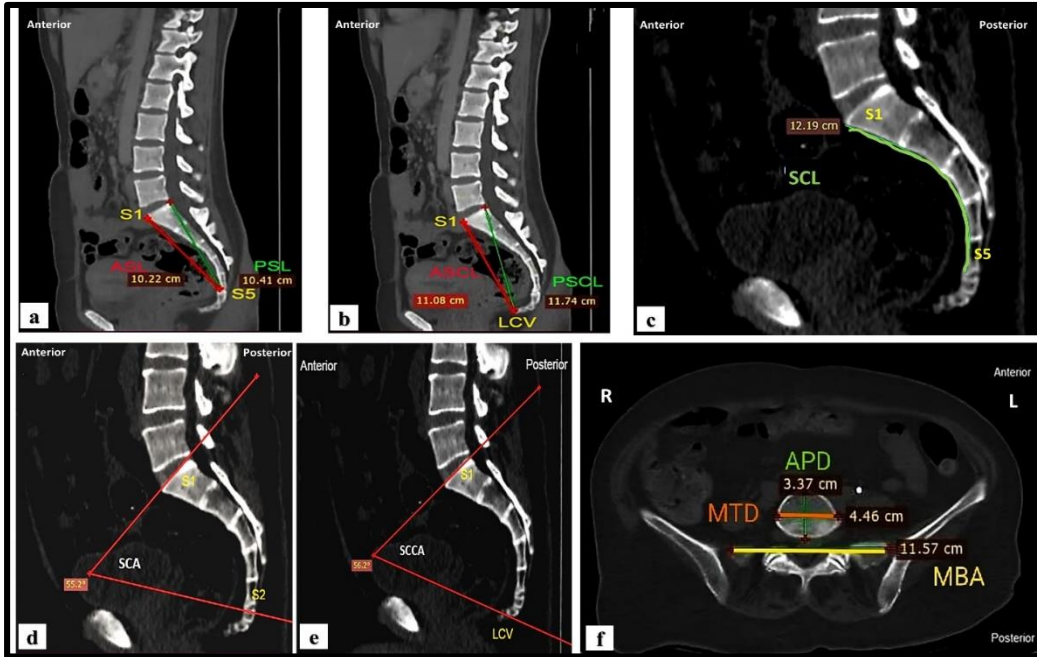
Multi-Detector Computed Tomography images for sacrococcygeal measurements used in the study. (a & b). Linear measurements of sacrum and coccyx in sagittal plane: ASL: anterior sacral length, PSL: posterior sacral length, ASCL: anterior sacrococcygeal length, PSCL: posterior sacrococcygeal length, S1: first sacral vertebra, S5: fifth sacral vertebra & LCV: last coccygeal vertebra. (c). curved measurement of the sacrum in sagittal plane: SCL: Sacral curve length, S1 & S5. (d). Sacral curve angle measurement in sagittal plane: SCA: Sacral curve angle, S1 & S5. (e). Sacrococcygeal curve angle measurement in sagittal plane: SCCA: Sacrococcygeal curve angle, S1, S5 & LCV. (f). Linear measurements of the sacral base in axial plane: MTD: Maximum transverse diameter of S1, APD: anteroposterior diameter of S1 and MBA: Maximum breadth of sacral alae.
